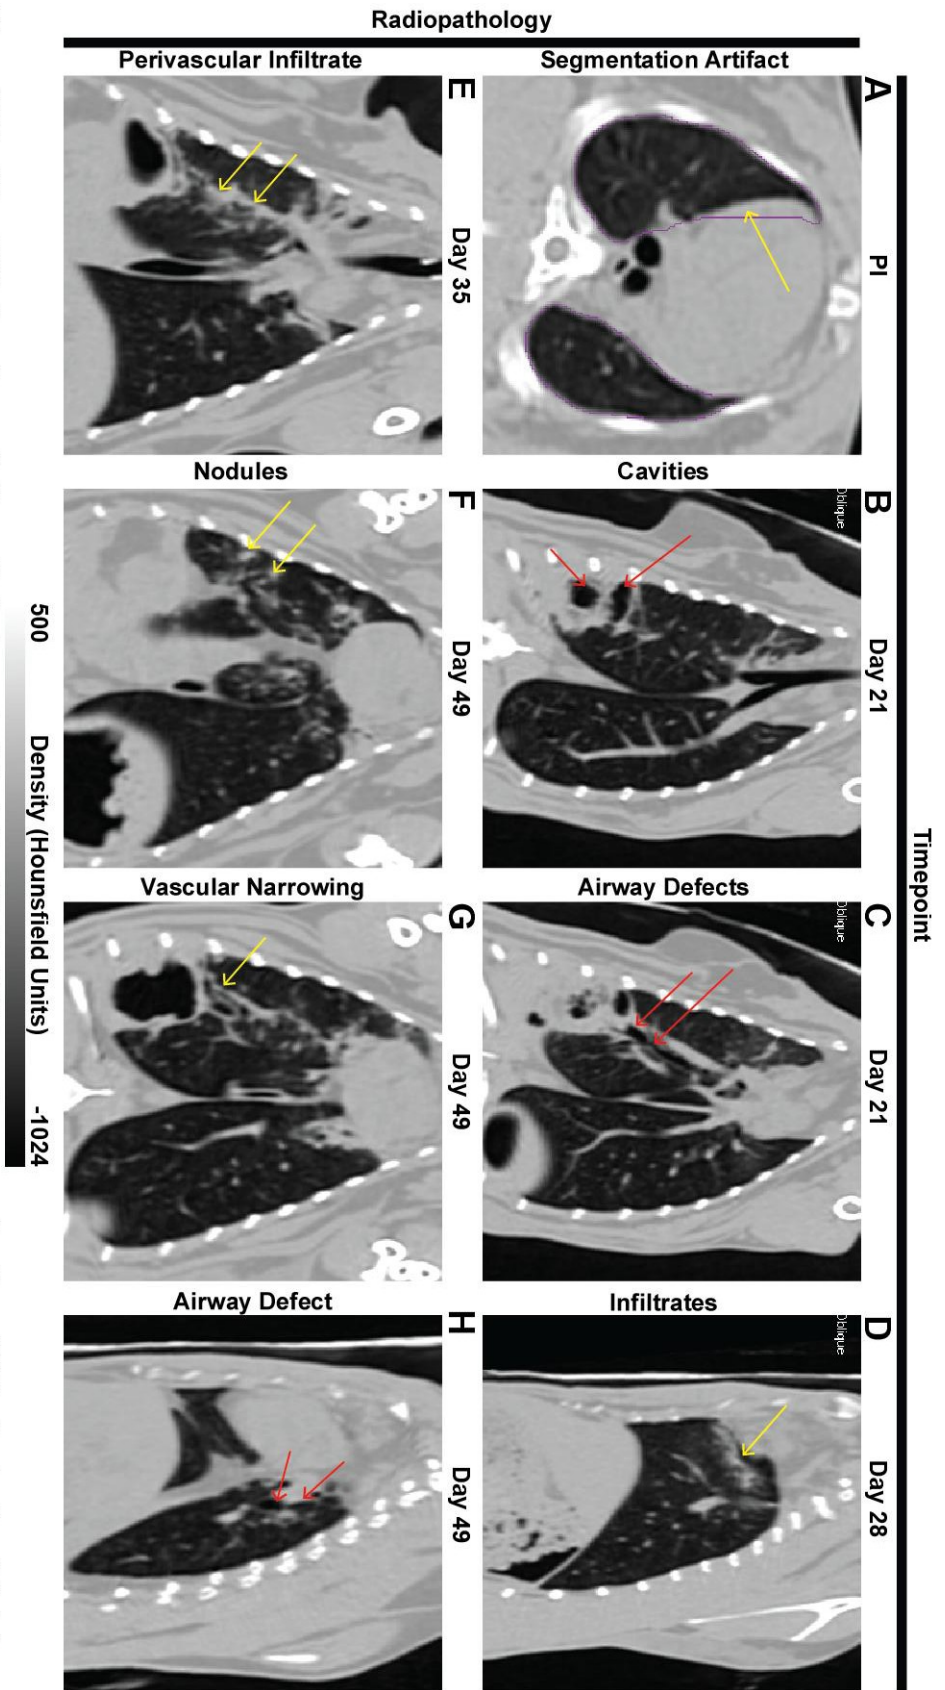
Traditional CT slices demonstrating pathologies and artefacts identified in 3D false colour reconstructions: (A) Cardiac border artefact: transverse section showing dense regions (yellow arrow) corresponding to cardiac tissue mistakenly placed into the lung field (purple line) during semi-automated segmentation. (B) Cavities identified at day 21 (red arrows). Coronal section. (C) Airway defects proximal to the region of disease are noted. There is a stricture proximal to a dilation in the airway (red arrows). Coronal section. (D) At day 28 an infiltrate is observed in the left upper lobe of the lung (yellow arrows). Sagittal section. (E) Perivascular infiltrates (yellow arrows). Coronal section. (F) Distinct nodules are noted adjacent to the cavity (yellow arrows). Coronal section. (G) A distinct narrowing of the pulmonary vasculature (yellow arrow). Coronal section. (H) Dilation of the bronchiole tree in the left upper lobe in the vicinity of the infiltrates (red arrows). Sagittal section.
